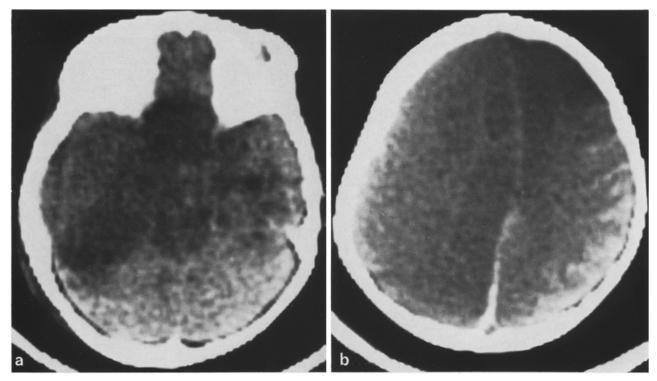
Acute cerebral infarction. 22-month-old infant: decreasing consciousness following head injury. A cephalohematoma was associated with extensive cutaneous injuries. There were no skeletal injuries. Unenhanced CT: marked right shift and extensive bilateral low density consistent with cerebral edema and infarction. The infant died: post-mortem examination confirmed cerebral infarction
